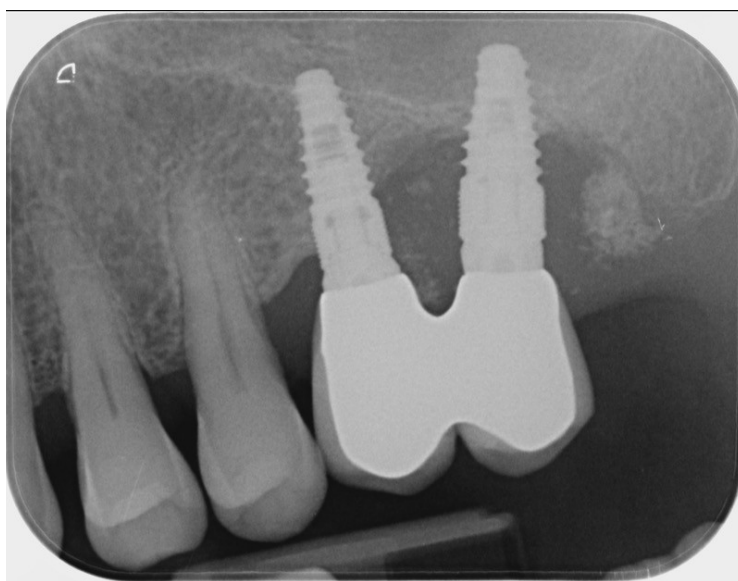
Periapical X-ray of implant sites 2.6-2.7
